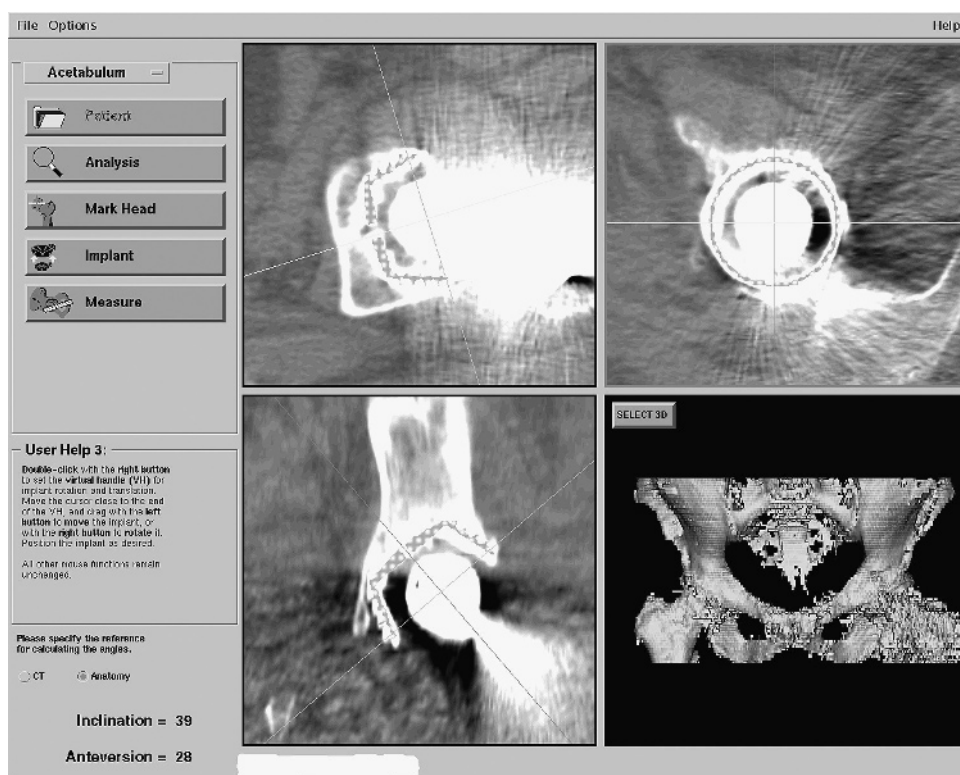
Computer screen view demonstrates three postoperative views through the center of the acetabulum from the computed tomographs including the sagittal, axial and frontal views followed by a three-dimensional model of the pelvis. Note the calculated acetabular inclination of 39 degrees and anteversion of 28 degrees.
